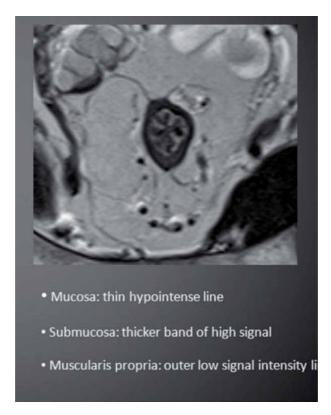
Mucosal layers of rectal wall (axial T2 weigted MR image).
